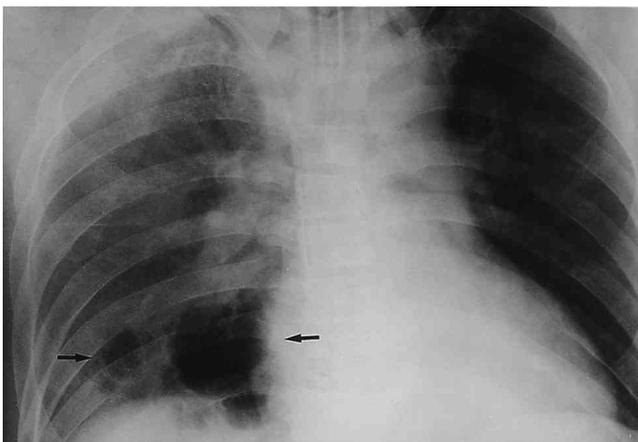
Oxygen toxicity in a 57-year-old man with inhalation burn. Chest radiograph taken three days after inhalation burn with ventilatory support and oxygen therapy shows pneumatoceles (arrows) formation in right lower lung. Diffuse haziness in right lung is due to pleural effusion.
